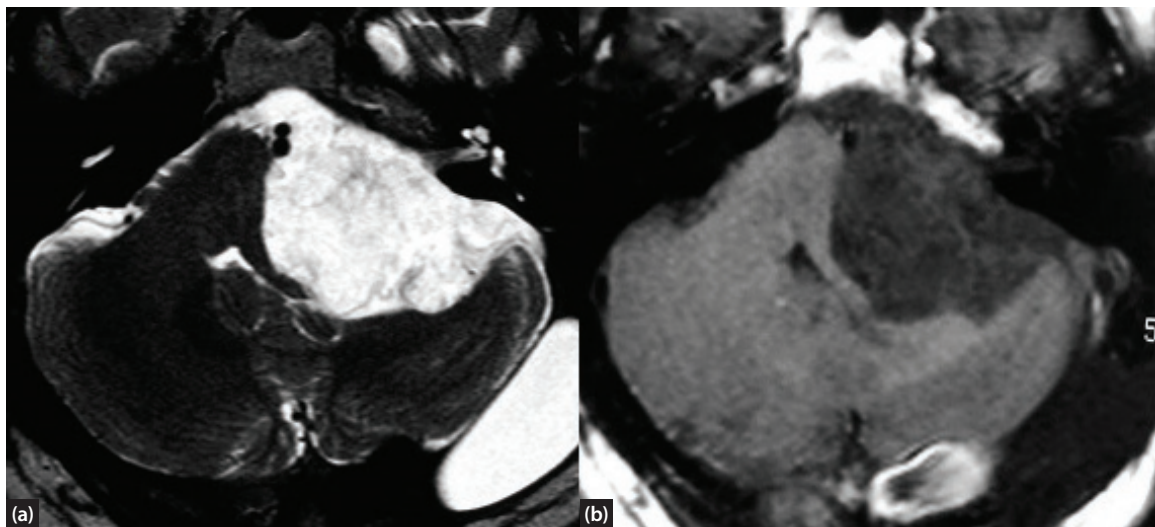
Axial MRI scans showing a large left CPA epidermoid. (a) T1-weighted scan without gadolinium enhancement. (b) T2-weighted scan.
